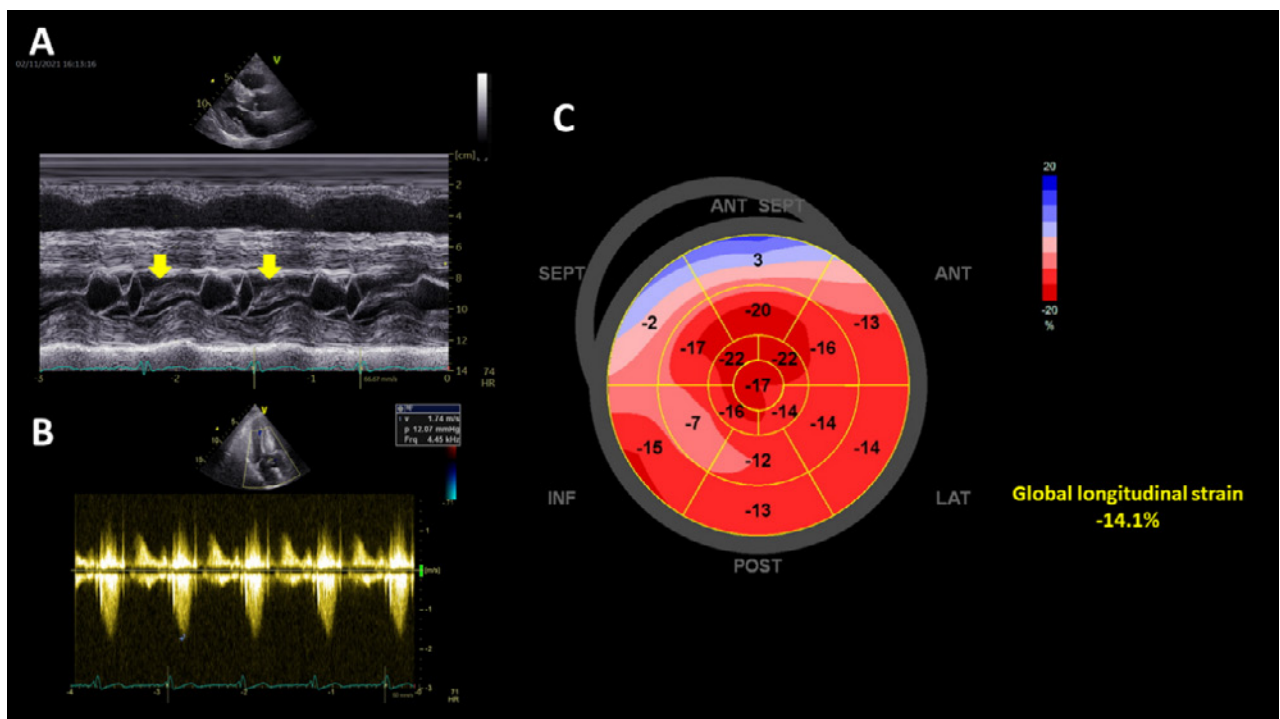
Panel A demonstrates systolic anterior motion of mitral valve (yellow arrow) in M-mode of case 3. Panel B shows no significant resting pressure gradient through left ventricular outflow tract by continuous Doppler. Bullseye mapping of longitudinal strain (panel C) shows decreased strain in basal septum (ANT SEPT = anteroseptal wall; SEPT = septal wall; INF = inferior wall; POST = posterior wall; LAT = lateral wall; ANT = anterior wall of LV). Global longitudinal strain -14.1%
